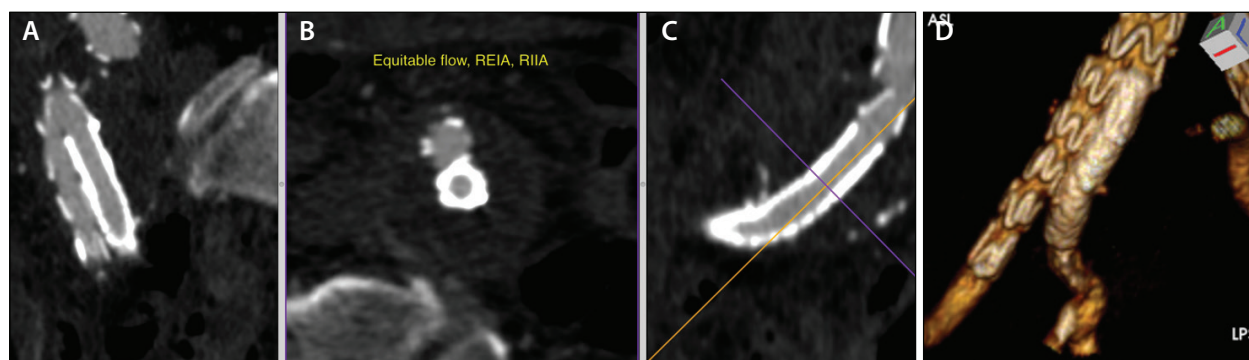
Follow-up CT scan showing the custom-made E-liac and good seal and flow in the right external and internal iliacs.
